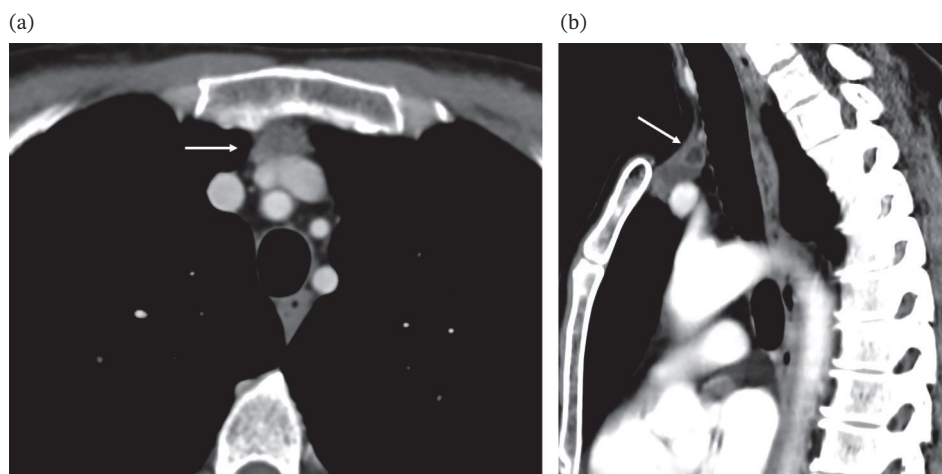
Axial and sagittal chest computed tomography showed (a) a small not-involved thymic gland (arrow) with (b) associated pretracheal cystic lesion (arrow).
